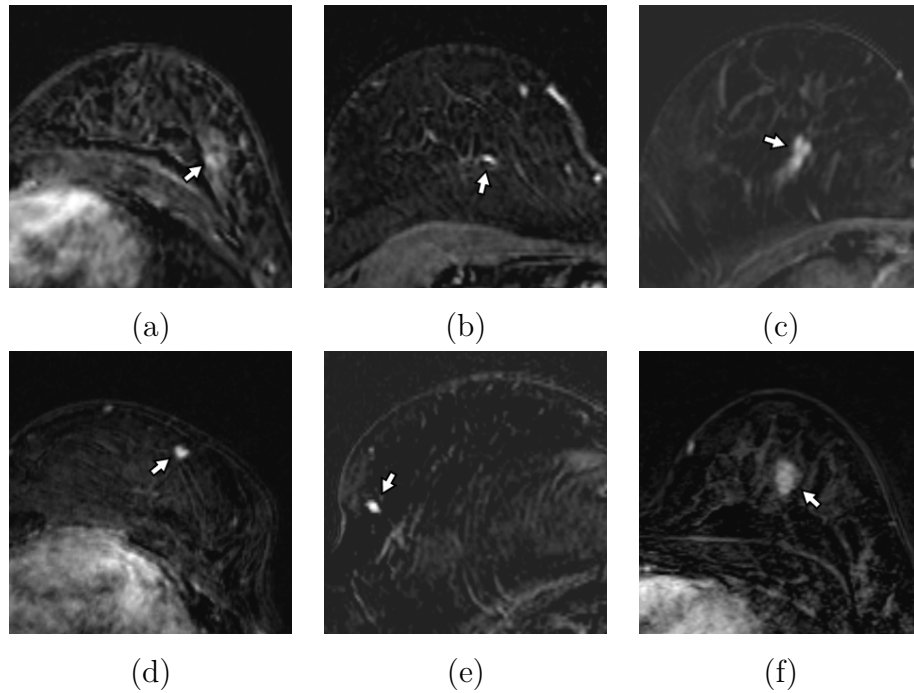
Subtraction images with breast cancer lesions (a-b) minimally visible and (c-f) visible on prior DCE-MRI studies. These lesions were automatically detected by the CAD system.
